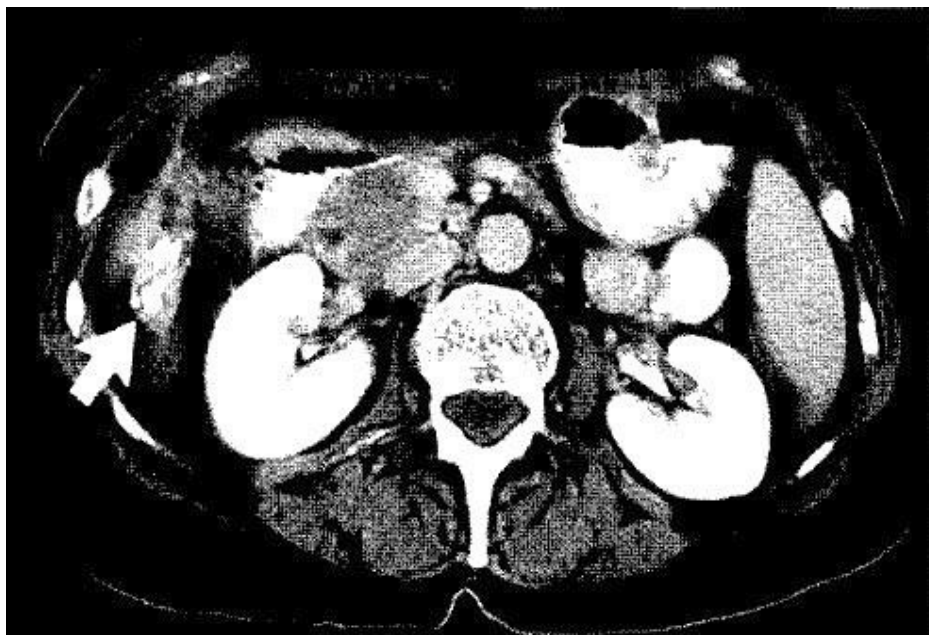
CT scan demonstrating intraperitoneal gallstones (arrow) with surrounding inflammatory reaction and fluid collection.
